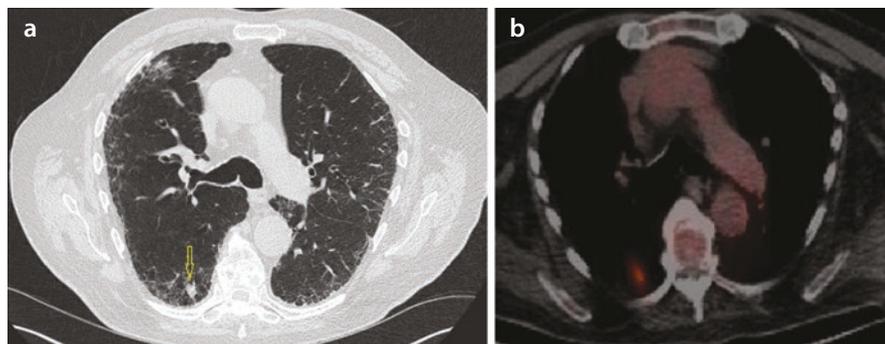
(a) CT chest showing areas of abnormal reticular disease, architectural distortion and traction bronchiectasis with a basilar, peripheral predominance. Solid nodule in the right lower lobe superior segment measures approximately 7×12 mm (arrow). (b) PET scan showing that the right lower lobe nodule is hypermetabolic. Pathology from wedge resection revealed adenocarcinoma
